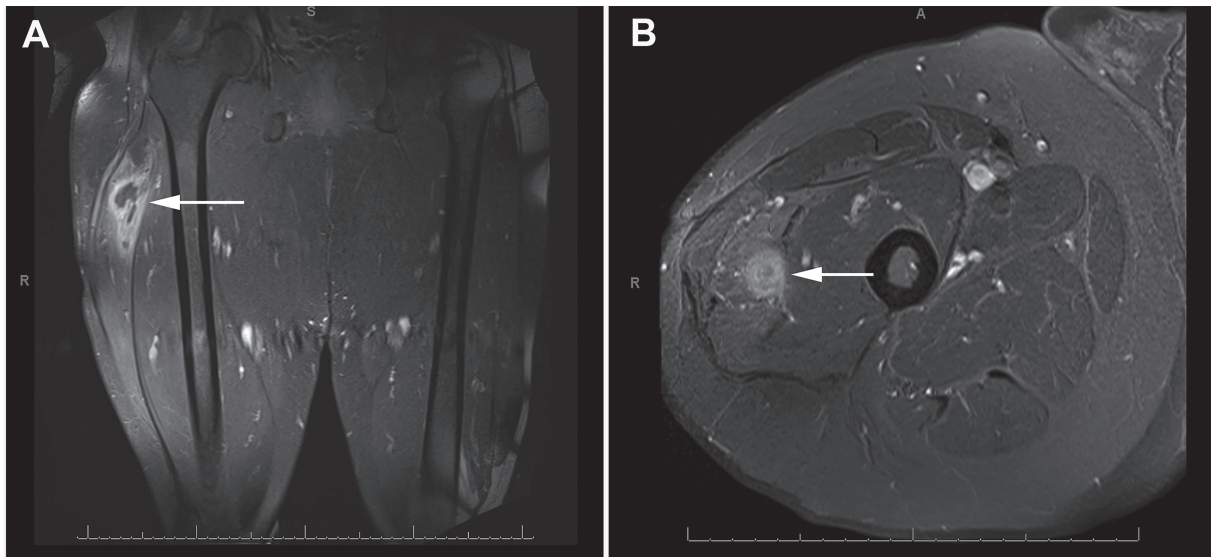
MRI of right thigh cavitation. (A) Coronal T1 sequence showing multifocal intermuscular and intramuscular rim-enhancing fluid collections within and around the vastus lateralis in the proximal anterior lateral thigh. (B) Transverse section of right thigh confirming fluid collection in the anterior compartment.
